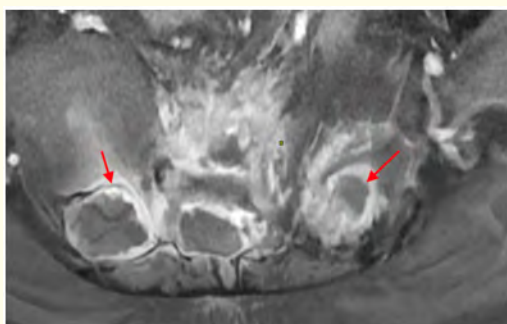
Axial contrast-enhanced T1-weighted image demonstrating peripheral enhancement of the cystic lesions (red arrows).
